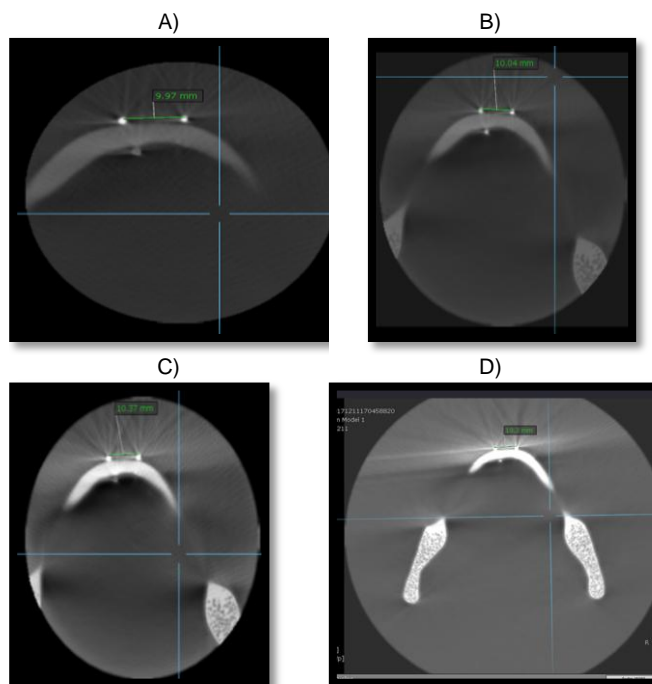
A) CBCT linear measurement of bone width on Small FOV CBCT images; B) CBCT linear measurement of bone width on Midi FOV CBCT images; C): CBCT linear measurement of bone width on Medium FOV CBCT images; D) CBCT linear measurement of bone width on Large FOV CBCT images
